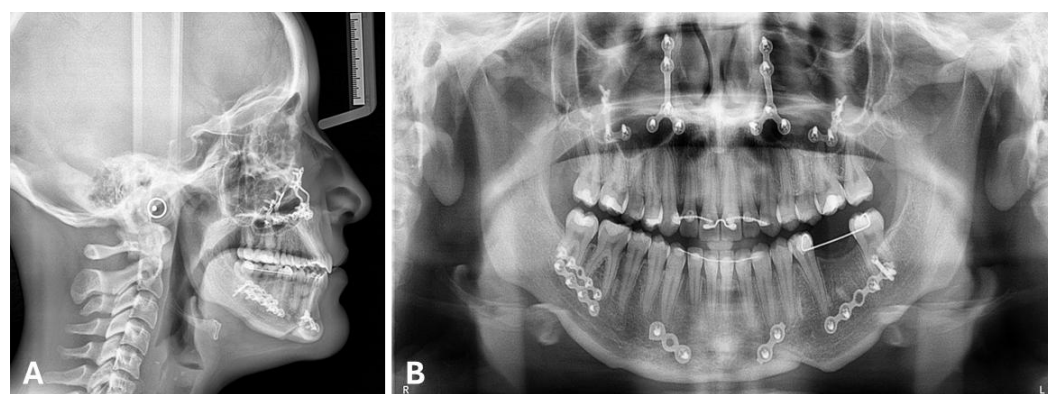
A and B. Post-operative lateral cephalometric radiograph and panoramic radiograph, showing fixation material and fixed retainers between 13 and 23, 33 and 43, and 35 and 37.
